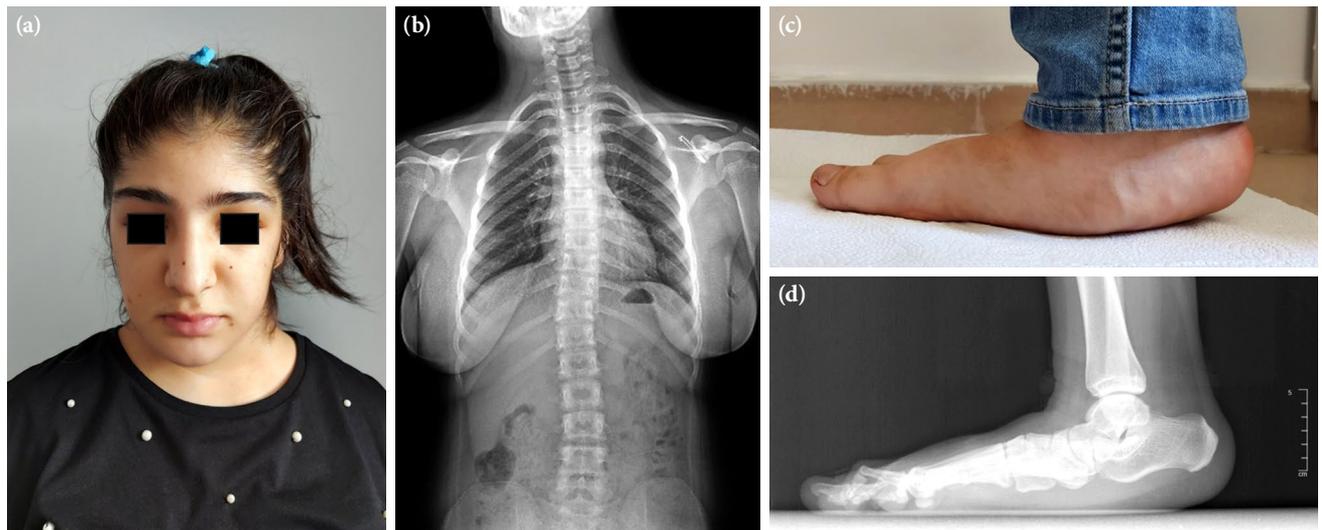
(a) Photograph of the patient showing typical facial appearance of Kabuki make-up syndrome. (b) Mild left cervicothoracic, right thoracolumbar, and left lumbar scoliosis seen in anteroposterior radiograph. (c) Photograph and (d) lateral radiograph showing pes planovalgus deformity in right foot.
